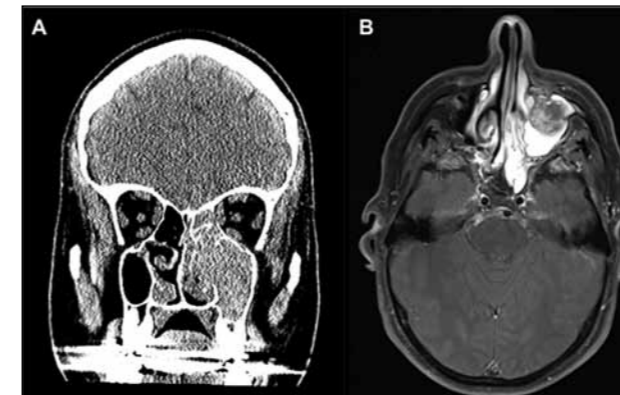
Coronal CT (A) and T1 gadolinium enhanced transverse MRI (B) of a left nasal mucosal melanoma, abutting the lamina papyracea with possible breach, and extending throughout the maxillary sinus and eroding its anterior wall.
